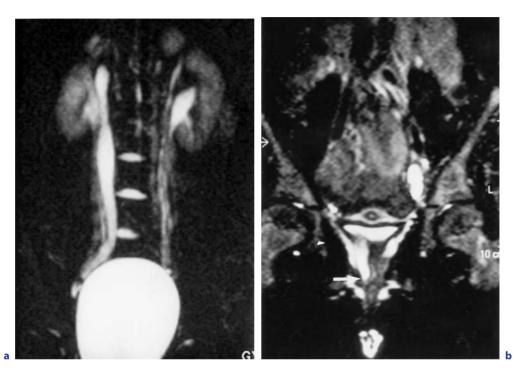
Ectopic vaginal insertion of an upper pole ureter (7-year-old girl with urinary dribbling). a MR urography T2-weighted sequence shows bilateral duplication with dilated right upper pole ureter. b MR urography on the bladder: vaginal ectopia of the ureter corresponding to the upper pole (*arrow*)
